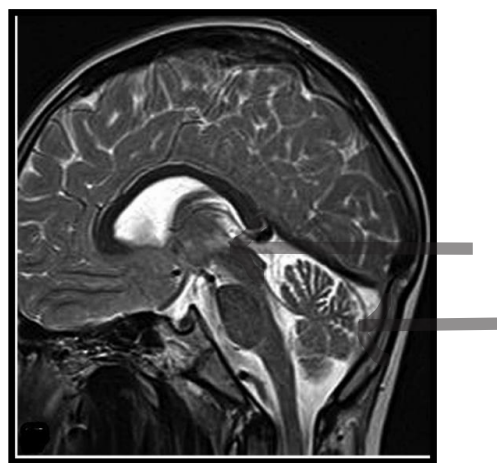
MRI Brain revealed vermian predominant pancerebellar atrophy with midbrain hyperintensities involving tectum, tegmentum.
